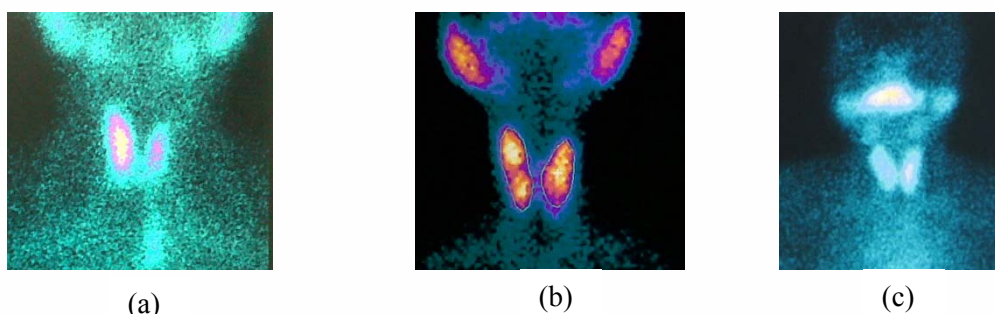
Thyroid scintigraphy images. a. Normal thyroid. b. Hyperthyroid. c. Cold nodule at right thyroid
